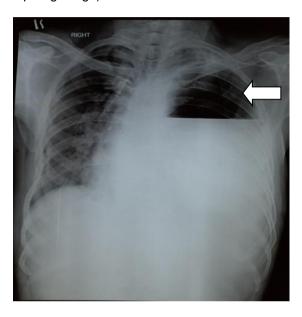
Chest X-Ray showing showing gastric air bubble
